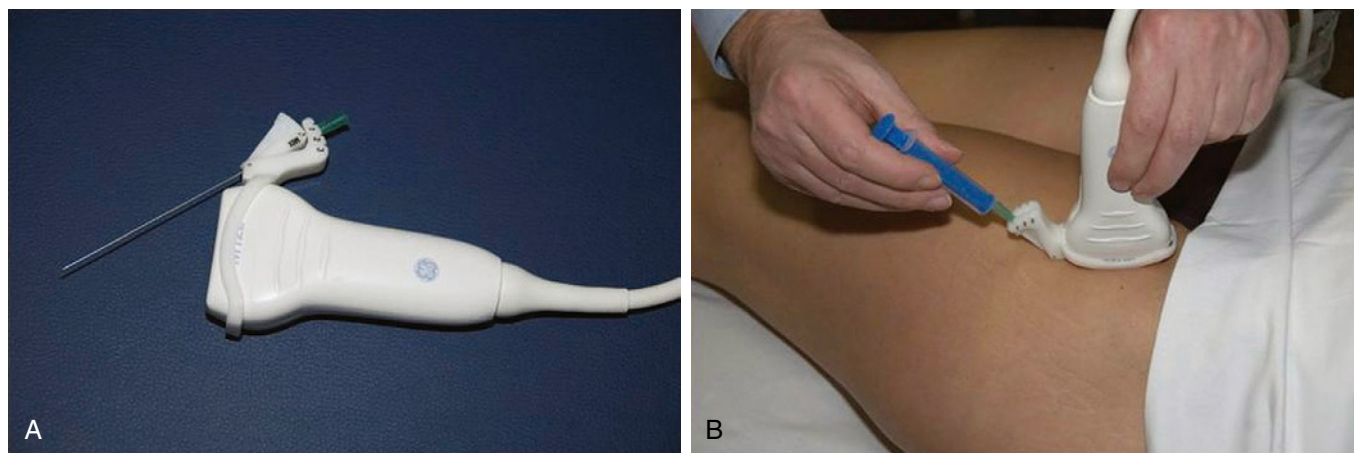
Guided injection is demonstrated. A, Attachable guided-injection device (GE injection kit). B, Ultrasound-guided intervention of the hip (anterior approach) uses the guided-injection technique (GE injection kit).
